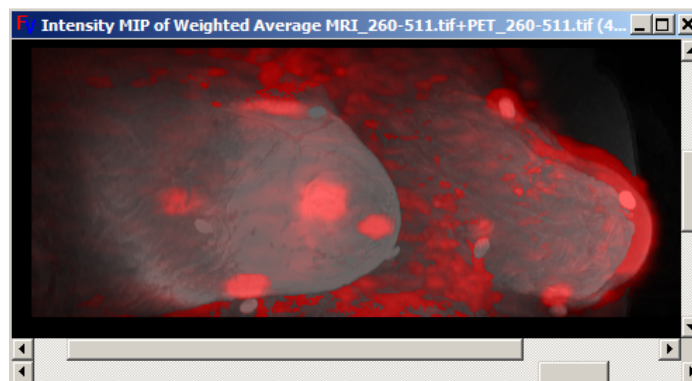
Color MIP from fused PET/MRI. Projection performed at an angle of 40 degrees (rays traced from right, anterior). Areas of higher activity (red) are visible along the breast surface. These correspond to the nipple region and the fiducial markers used during PET imaging.
